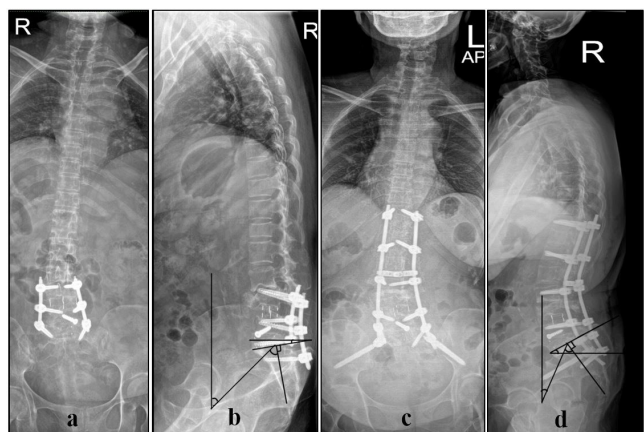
a-b - Preoperative radiograph with measured Pelvic Incidence (PI) of 53°, lumbar lordosis angle (LLA) of 20.8°. Note here the marked loss of lumbar lordosis with high Pelvic Tilt angle of 42.2° (Normal Value: 12-18°). the right; c-d - Postoperative radiograph with measured LLA=43.9°, PI = 53°
